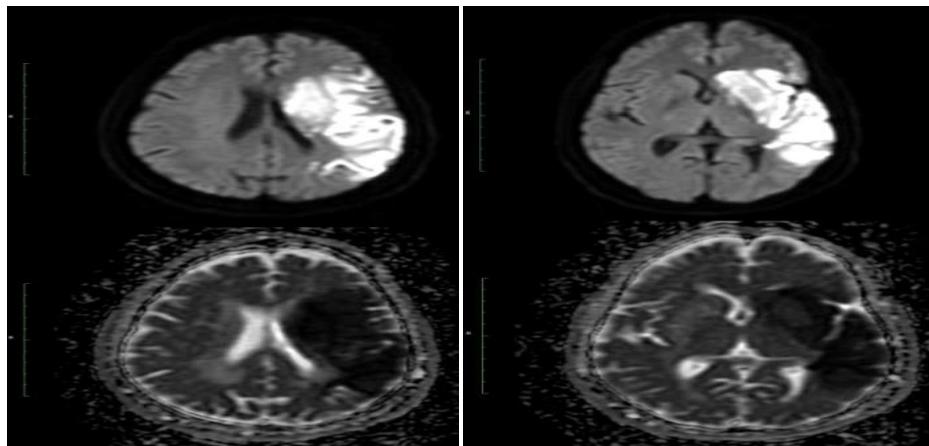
MRI-DWI ADC image shows restriction in left caudate nucleus, left internal capsule, M1,M2,M3,M4 & M5 with corresponding reduced diffusivity in ADC map in MCA artery distribution in a patient who presented with right hemiparesis
